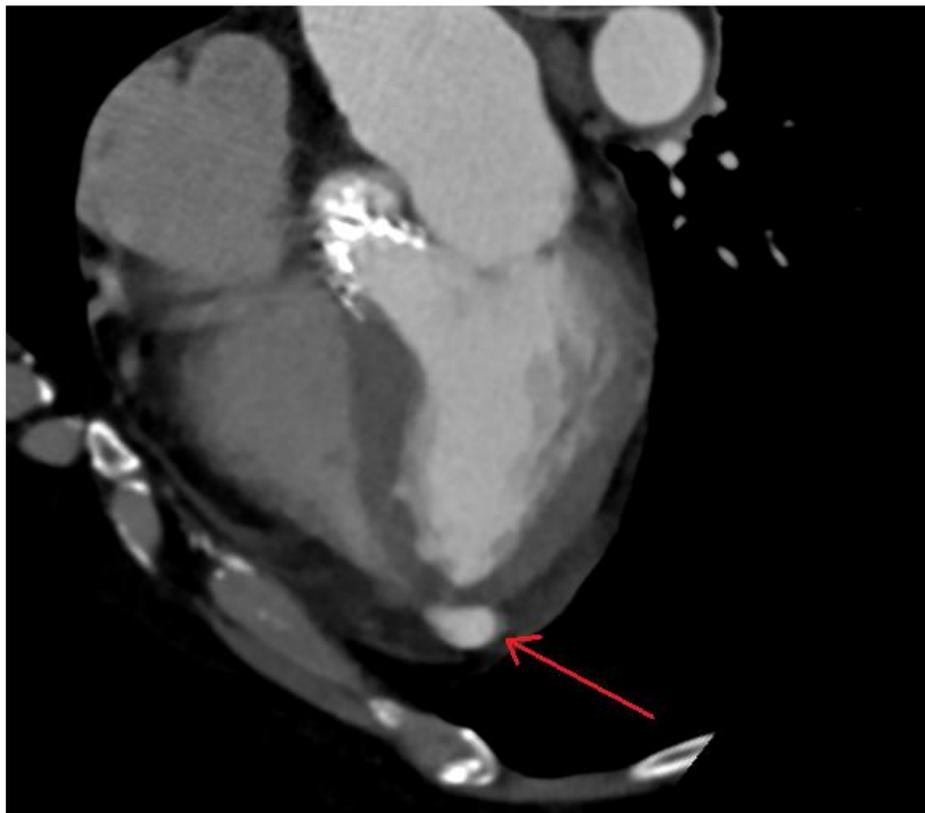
A cardiac CT scan revealed the presence of contrast material outside of the vasculature, indicative of a pseudoaneurysm (red arrow).*
